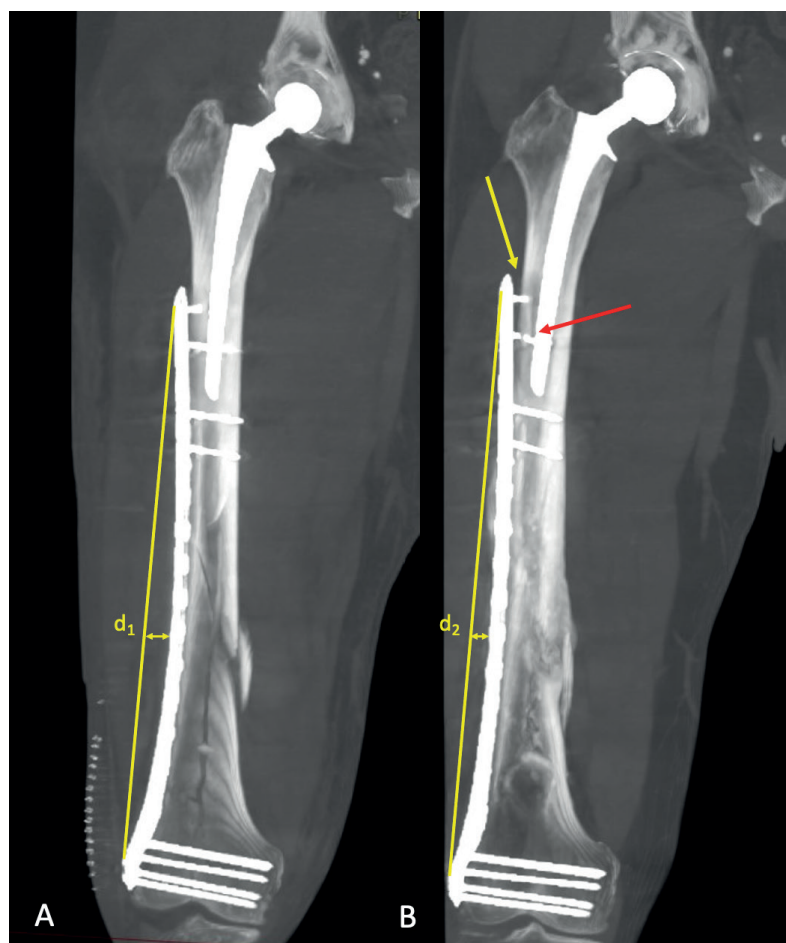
A; Patient with a 32(c) IV.3C fracture with normal bone density and a BMI of 33. The fracture subsidence was discreet at the medial and lateral condyle, 2.2 mm and 2.6 mm, respectively. B; At 52 weeks the total femoral shortening was 10 mm and the varus angulation had increased by 4.3°. By increasing the thickness of the CT slices to 50 mm, the contours of the plate could be made visible. The distance (d_x) between a line drawn from both tips of the plate and a determined reference on the plate shows that the plate has been permanently deformed at the 52-week follow-up. The red arrow is pointing at broken screw and the yellow arrow in pointing at an increased gap between the proximal tip of the plate and the femoral shaft.
